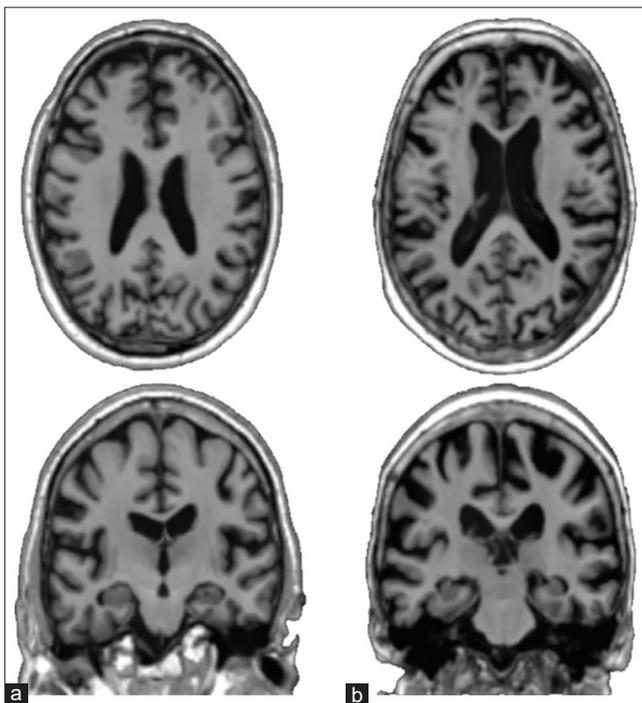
Magnetic resonance imaging sample, (a) a normal control and (b) a Alzheimer's disease patient
